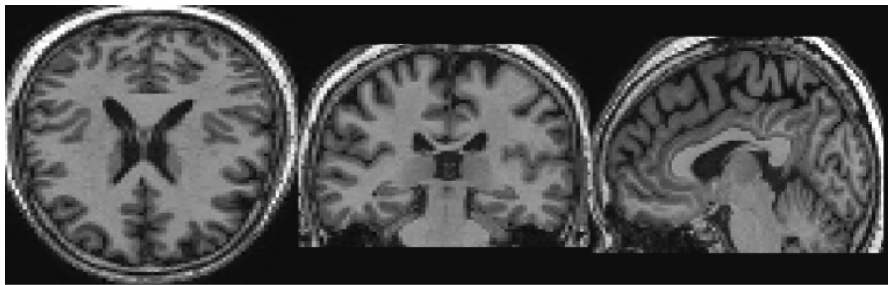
Slices of an MRI scan of AD patient (from left to right, in axial view, coronal view, and sagittal view)
